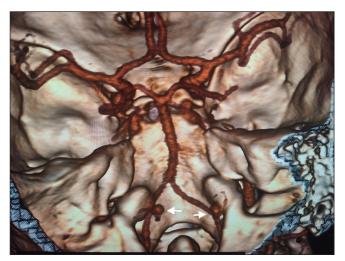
Computed tomography angiography image of the brain showing bilateral aneurysms at the origin of the posterior inferior cerebellar artery (white arrows).
